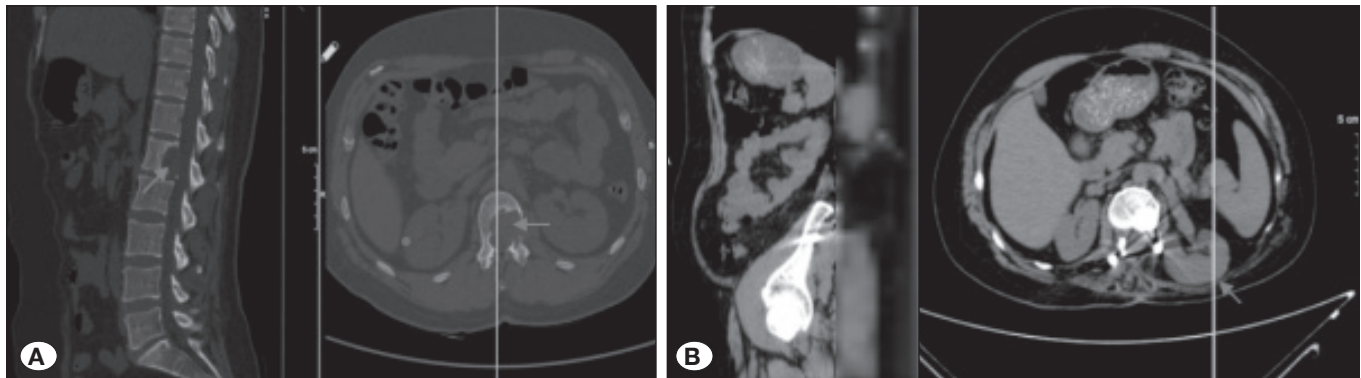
Preoperative CT (A) midsagittal and midaxial reconstruction shows a cystic lesion located in the L1 vertebra corpus (arrows), postoperative CT (B) sagittal and axial reconstruction shows left renal hernias (arrows).
